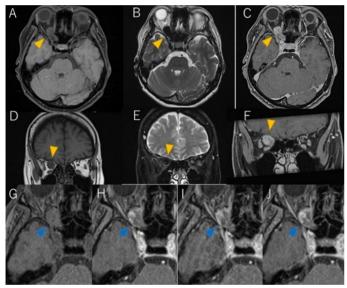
MRI revealed a 30x12x12 mm tumorous lesion that had extended from the right orbit through the optic canal to the intracranial space, and was compressing the optic nerve. T1- (A, D) and T2- (B, E) weighted images showed low signals and heterogeneous contrast effects with Gadolinium (C, F) (yellow arrows). Dynamic imaging taken every 30 seconds after gadolinium contrast injection showed that the tumor (blue arrows) was slowly enhanced (G, H, I, J).
